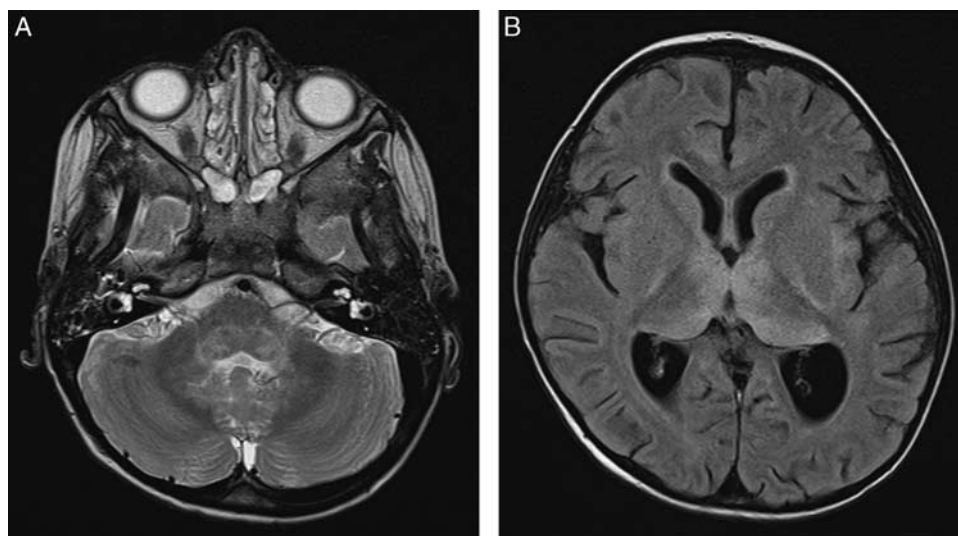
Magnetic resonance imaging showing T2 axial section (A) and FLAIR (B) axial sequences of the brain of 5-year-old boy with enterovirus encephalitis. Imaging reveal symmetrical high signal of the basal ganglia, brain stem and around fourth ventricle.
